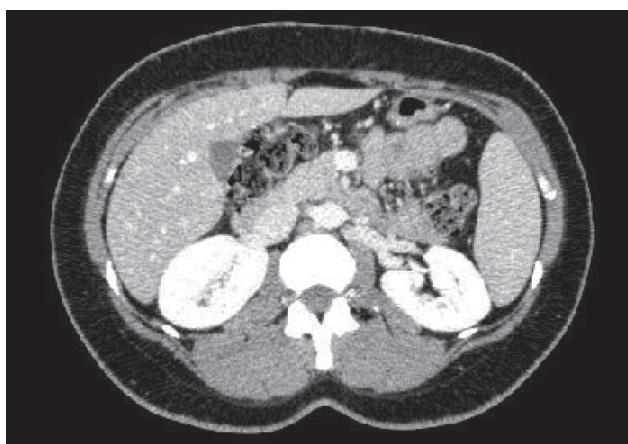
Computed tomography of the upper abdomen in a 33-year-old female with hypertension: The left renal vein is constricted between the vertebral body and the aorta (nutcracker syndrome).
